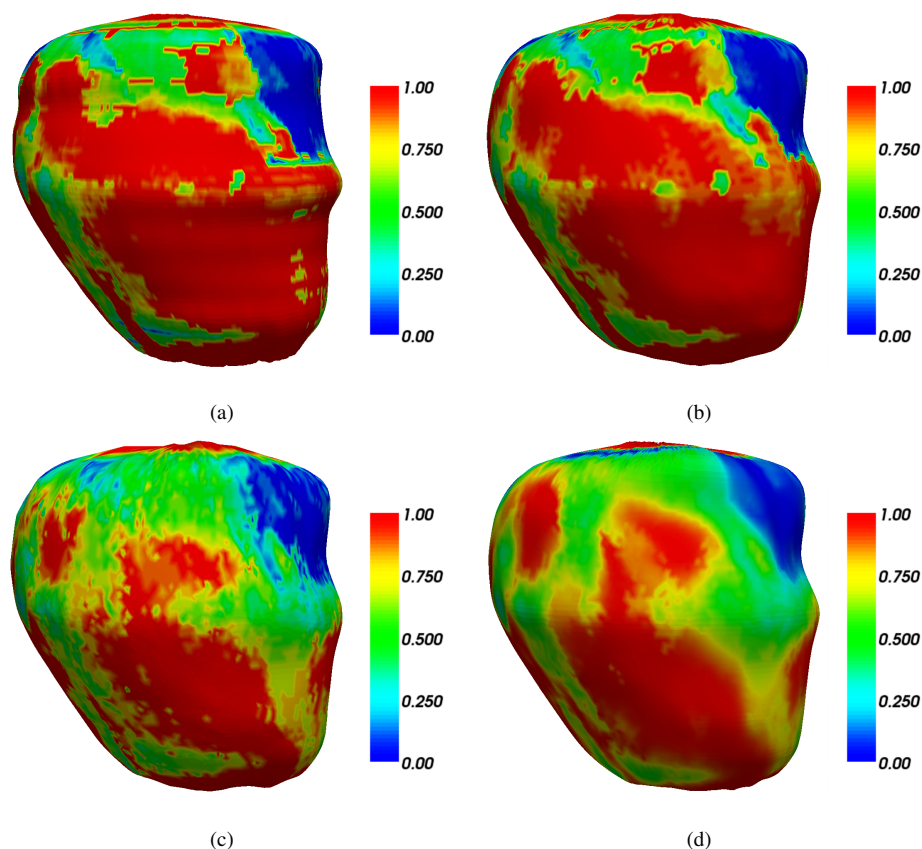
3D transmurality maps of an interpolated CE-MRI volume, using the transmurality method proposed by: (a) Nazarian et al. [11], (b) Elnakib et al. [20], (c) Schuijf et al. [19], and (d) this paper.
